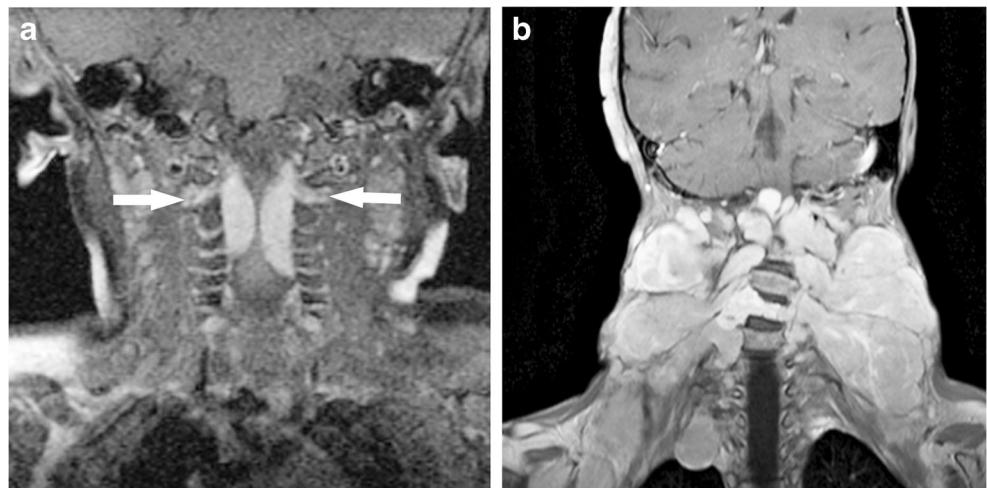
Neurofibromatosis type 2 with multiple cervicothoracic schwannomas gradually increasing over time, leading to cord compression in an 11-year-old boy. Targeted coronal fat-suppressed T1-weighted post-contrast images of the cervical spine (a) on initial imaging at 8 months old show extradural lesions with foraminal extension (*arrows*), and (b) 10 years later, exuberant paravertebral masses
